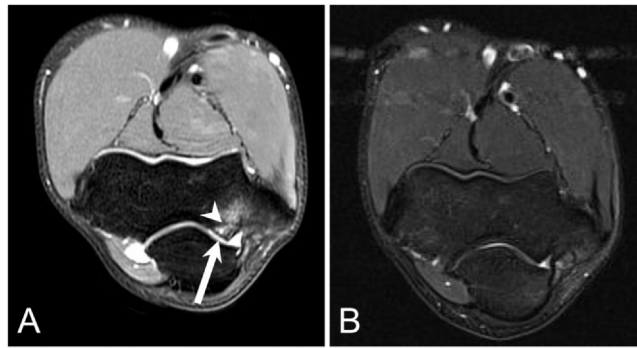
Professional baseball pitcher presents with medial-sided elbow pain and burning with throwing. Axial PD FS MR arthrogram image (A) demonstrates high-grade chondrosis involving the posteromedial trochlea (arrow) with underlying subchondral bone marrow edema and cystic change (arrowhead), findings typical for posteromedial impingement. These findings developed over the duration of this athlete's pitching career, as a T2 axial FS MR image (B) from baseline elbow MRI obtained 3 years prior was normal. FS, fat saturation; MR, magnetic resonance; MRI, magnetic resonance imaging; PD, proton density.
